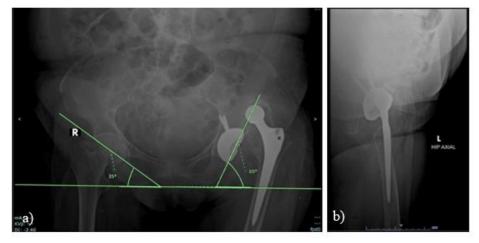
Pelvic x-ray, anteroposterior (a) and axial (b) view. Left acetabular inclination: 65°; with visible left hip implant dislocation, pseudoacetabulum, and invisible left greater trochanter
